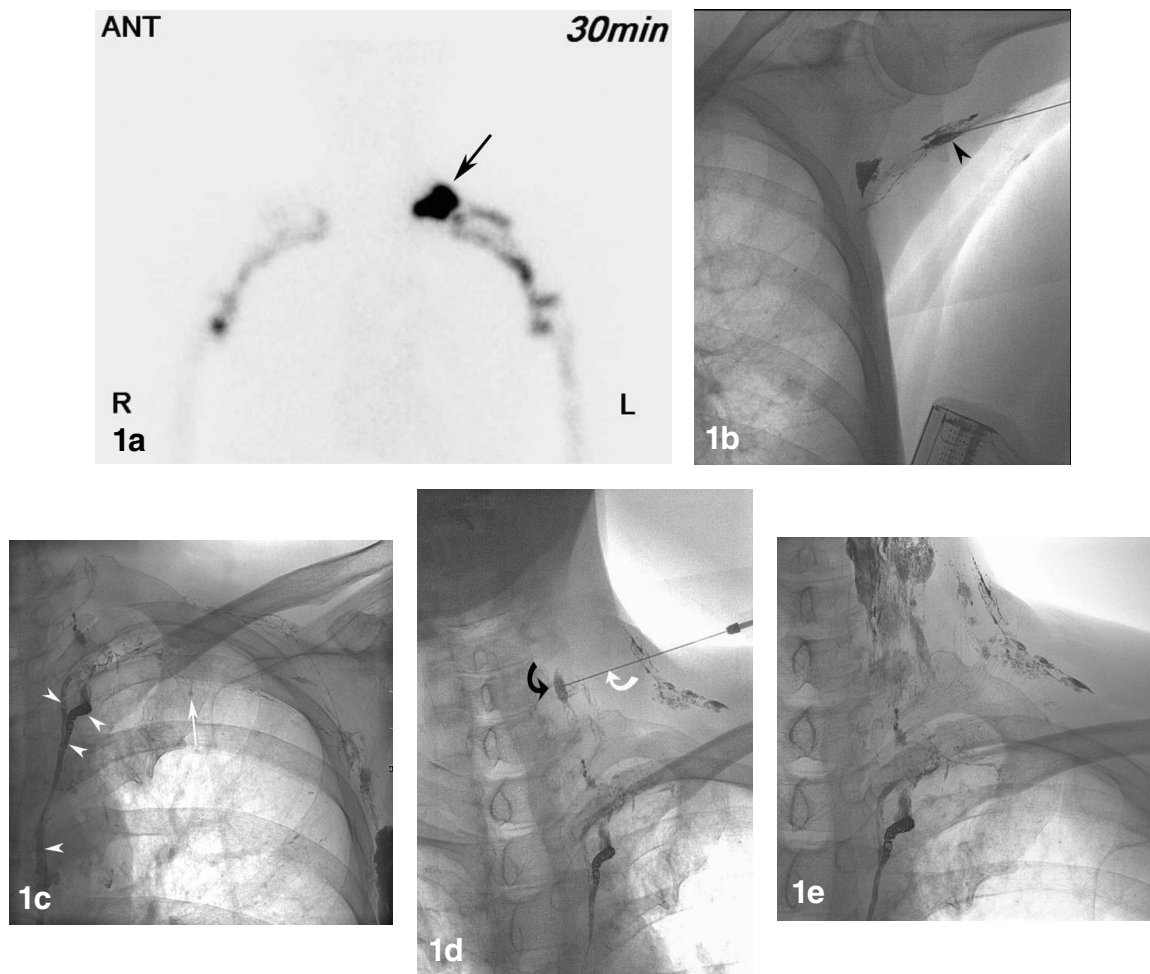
A 61-year-old man underwent thoracic duct embolization to treat a lymphocele that developed after a cervical transverse incision. (a) Upper limb lymphoscintigraphy was performed with technetium-99m-labeled human serum albumin and the anterior image taken 30 minutes after injection shows leaked tracer accumulation at the left clavicle (black arrow). (b,c) The first therapeutic lymphangiography performed with lipiodol injected into a left axillary lymph node (b, black arrow head) highlighted lipiodol extravasation into the lymphocele (c, white arrow). The prior thoracic duct embolization using a coil and sclerosing agent N-butyl-2-cyanoacrylate is also seen in this image (c, white arrow heads). (d,e) Twenty-two days after the first procedure, a second therapeutic lymphangiography was performed using a left cervical lymph node (d, curved black arrow) and puncture needle (d, curved white arrow). Although lipiodol extravasation is not observed (e), lymphatic leakage stopped 2 days later.
